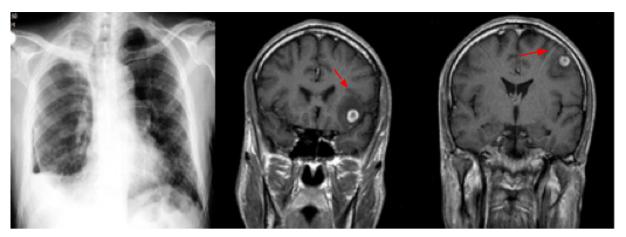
Chest x-ray and cranial MR imaging of the first patient
